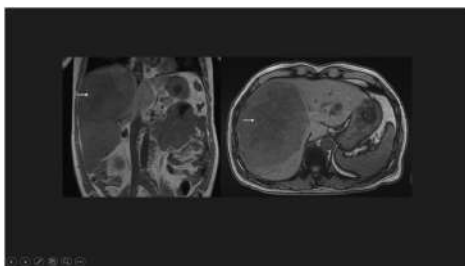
Computed tomography scan of liver mass.
